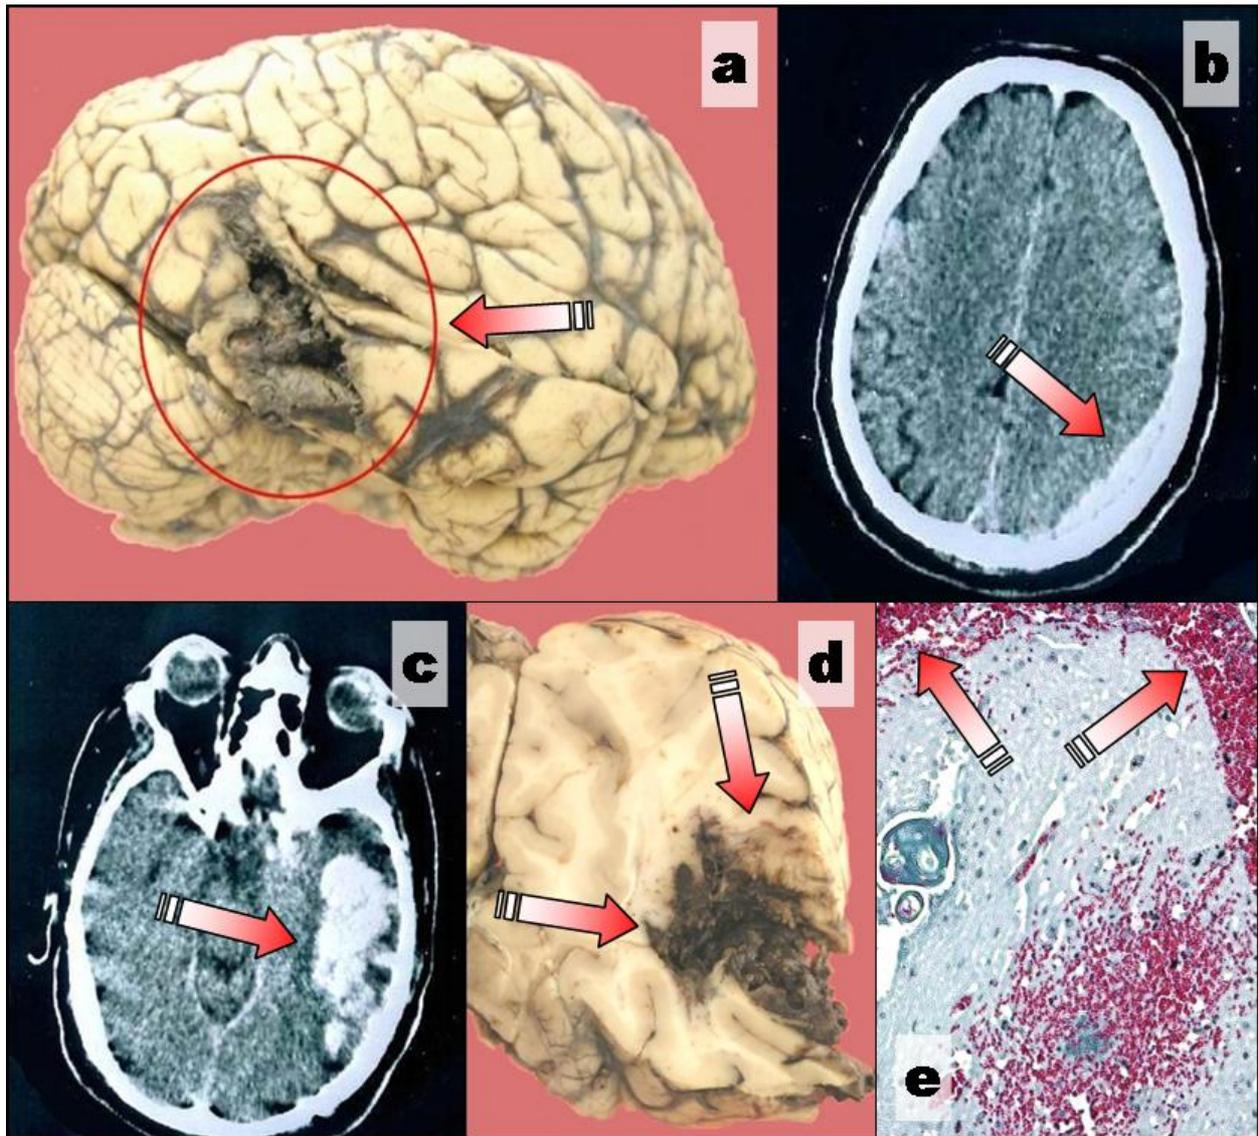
Right side frontal-temporal-parietal-occipital hematoma: (a) Effraction at temporal lobe level; (b) Parietal-occipital effusion; (c) CT aspect; (d) Necropsy gross aspect on Pitres section; (e) Hemorrhage extension in the subarachnoid space.
